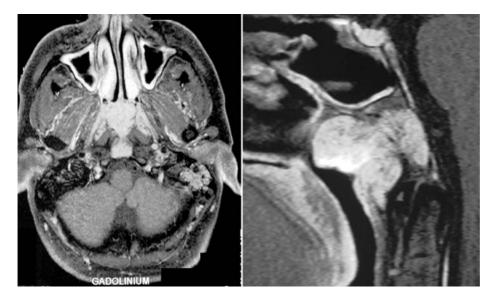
T1 weighted transverse and sagittal MRI scan after gadolinium perfusion demonstrating the retro pharyngeal mass infiltrating the clivus and entering into contact with the dura. The mass is homogenously enhanced by contrast perfusion
